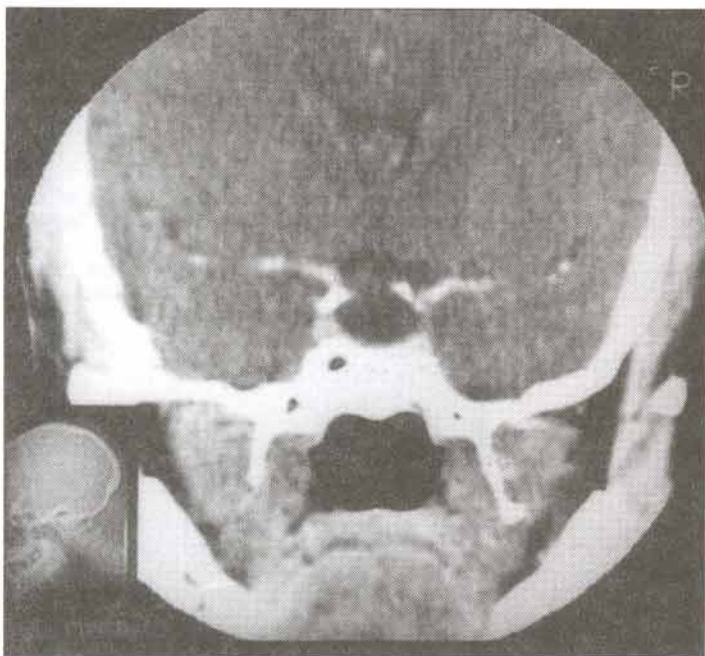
Post contrast coronal CT scan picture of the sella turcica demonstrating intra sella cerebrospinal fluid
